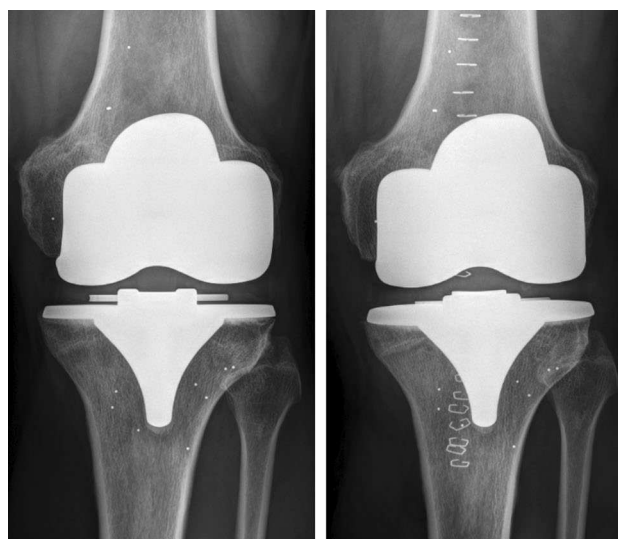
Direct and 5-year postoperative X-ray of the MB-TKA with MB-RSA beads
